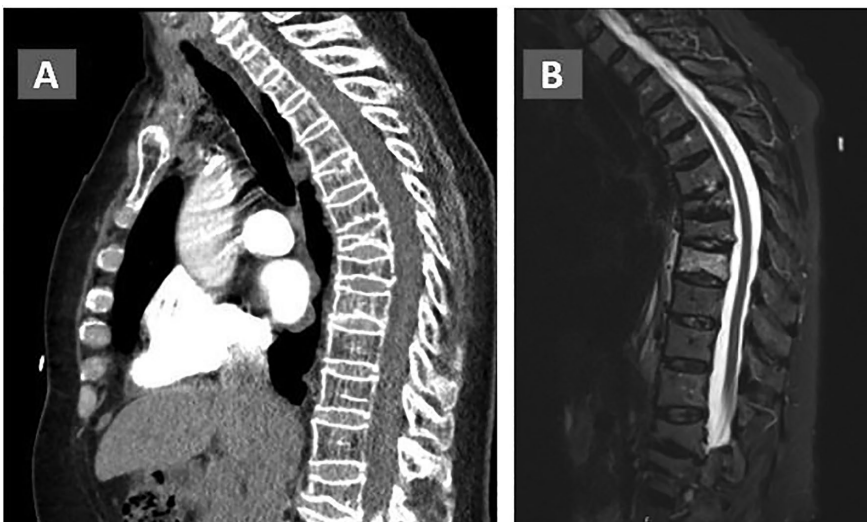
Demonstration of MRI STIR sequences in identifying the acuity of fracture, in patients with multiple vertebral body compression fractures. The acute fracture with bone marrow edema will be bright on STIR while chronic or remote fractures will remain isointense with adjacent normal vertebral bodies (Figures A and B).
